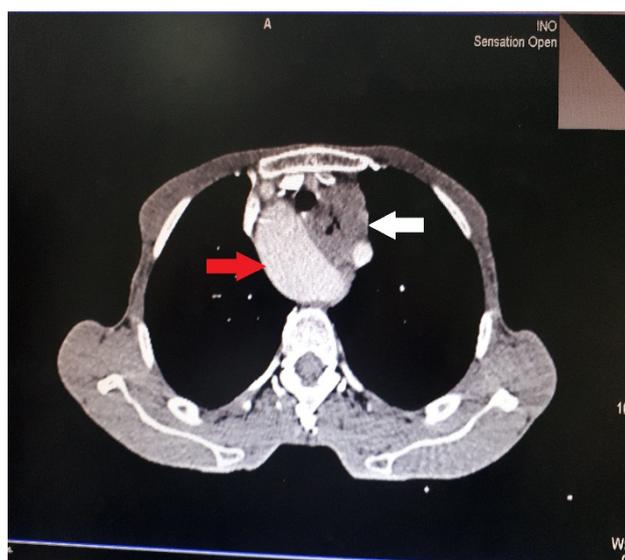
Panel A: A CT scan (axial plane) of the chest showing a right aortic arch (red arrow) and an esophageal cancer (white arrow).
